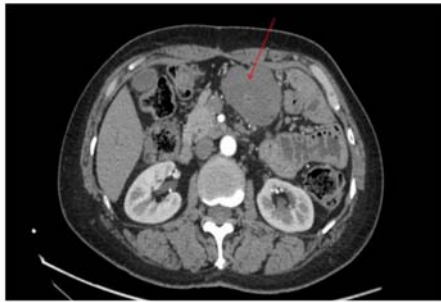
Abdominal CT scan before treatment with apatinib and celecoxib.
